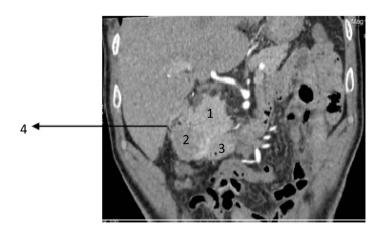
Coronal CT enhanced MPR exhibits soft tissue tumor mass showing slightly. heterogeneous enhancement at the uncinate process of head of pancreas. (1-Head of pancreas, 2-tumor mass, 3-2nd part of duodenum, 4-colon.)
